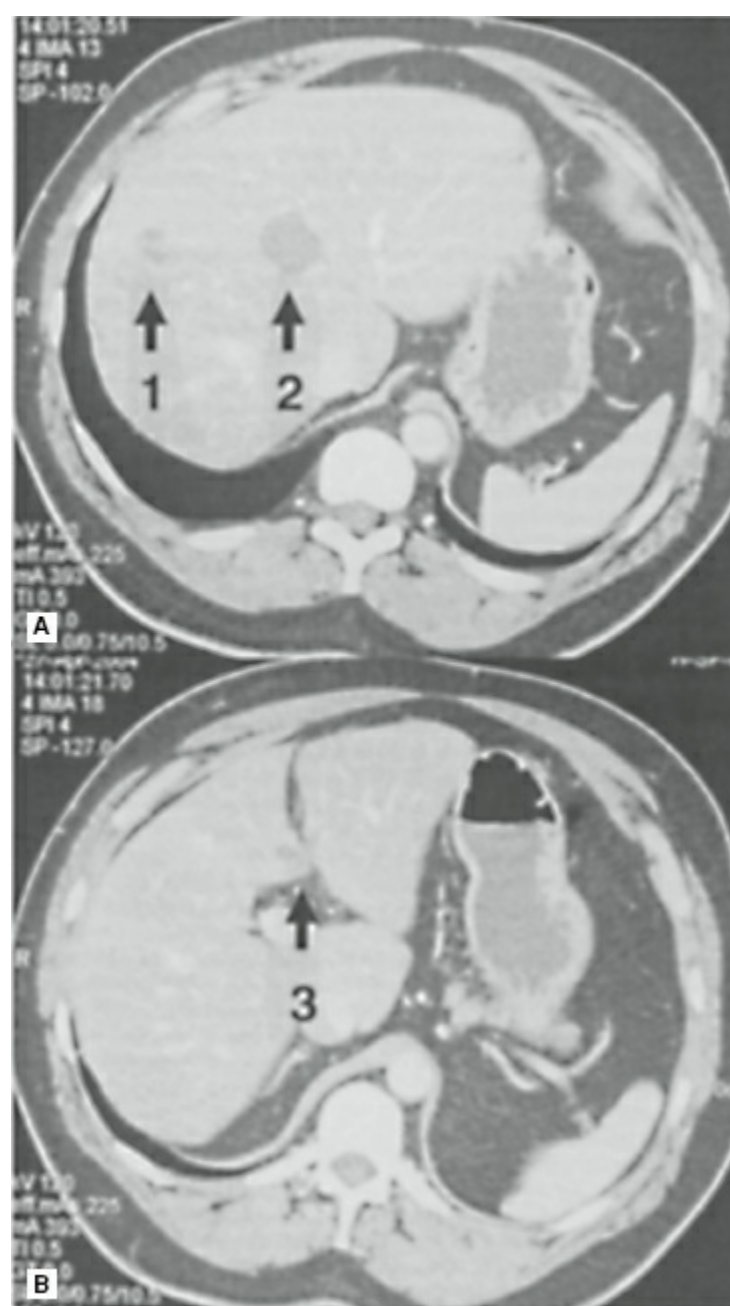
Portal venous phase of computed tomography (CT) scan from a patient with a history of colorectal cancer and three lesions in the liver. Lesion 1 in segment VIII is irregular and rim enhancing and was a colorectal cancer metastasis. Lesion 2 straddling segments IV and VIII has smooth borders, is not rim enhancing, and was found to be a cyst. Lesion 3 straddling segments IV and III across the umbilical fissure is irregular and rim enhancing and was a colorectal cancer metastasis.
